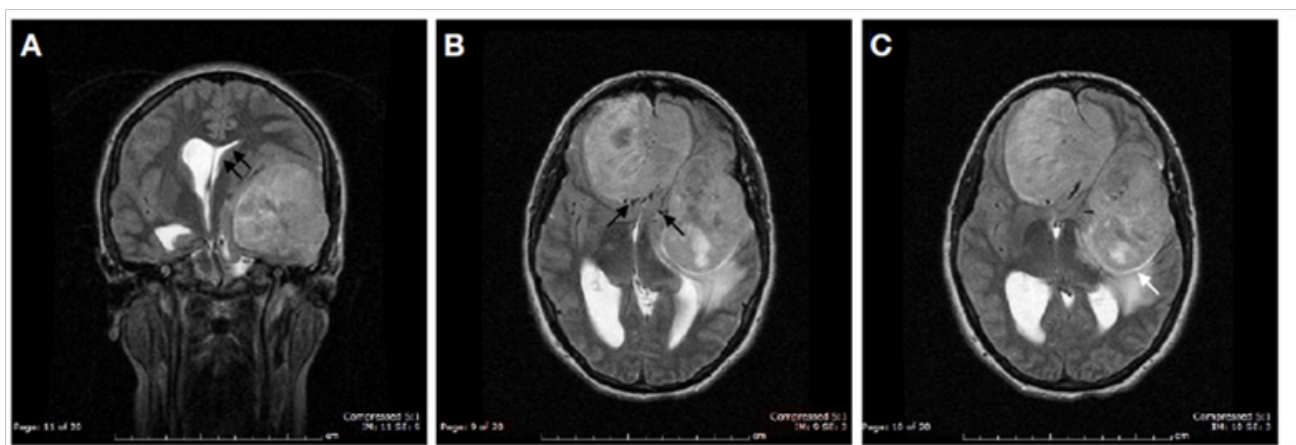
(A) T1 Gadolinium enhanced sagittal MRI demonstrate the olfactory Groove meningioma. Hyperintense to grey matter and extends anteriorly along the anterior cranial fossa floor. (B,C) Axial T2-weighted sequence MRI demonstrates the important mass effect and ventricular compression due to the giant meningiomas. It also highlights the normal arteries involved (Black arrows).
